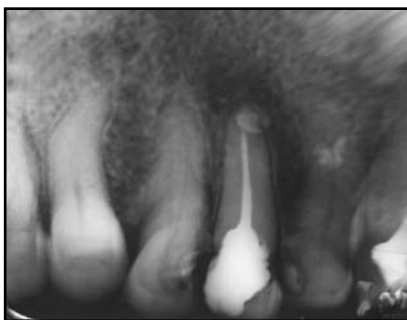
Radiographic image of 13 one month after MTA treatment evidences beginning of bone deposition
